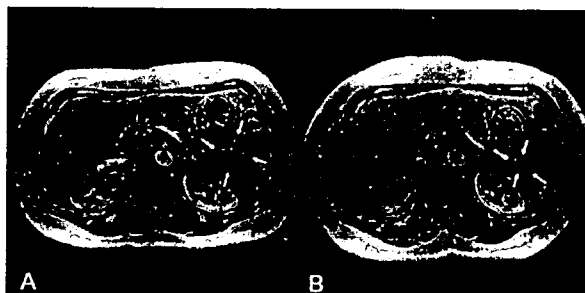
Abdominal MRI with contrast enhancement (A) Preoperative. A solid mass with cystic components was shown with contrast enhancement in the pancreatic tail. (B) Postoperative (7 months after operation). The mass diminished after the total removal of the ACTH-secreting pituitary adenoma.
